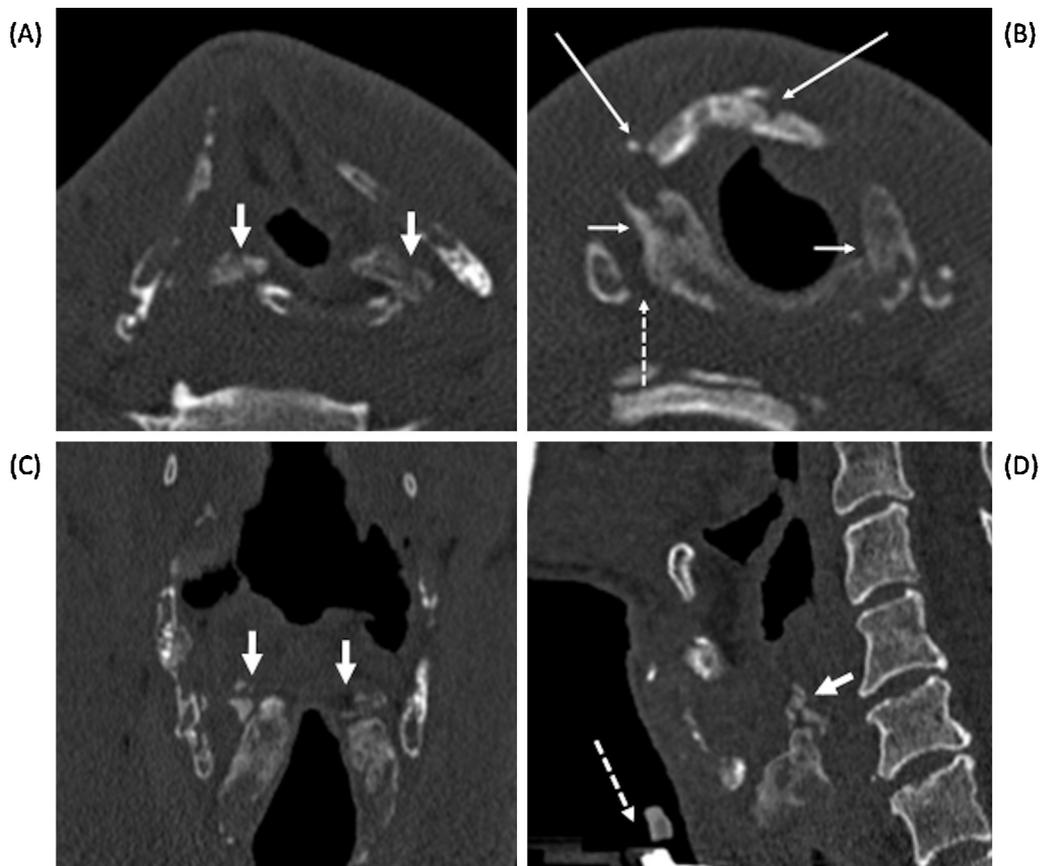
Major laryngeal trauma with shattered ossified cartilages and acute airway impairment necessitating tracheotomy prior to CT. Axial bone window images at the glottic (A) and subglottic level (B), coronal (C) and sagittal (D) 2D MPR show multiple fractures involving the thyroid cartilage (thin long arrows in B), the cricoid (short thin arrows in B) and the arytenoids (short thick arrows in A, C and D). Widening of the right crico-thyroid distance (dashed arrow in B) suggesting disjunction of the right crico-thyroid joint. Tracheostomy tube (dashed arrow in D).
